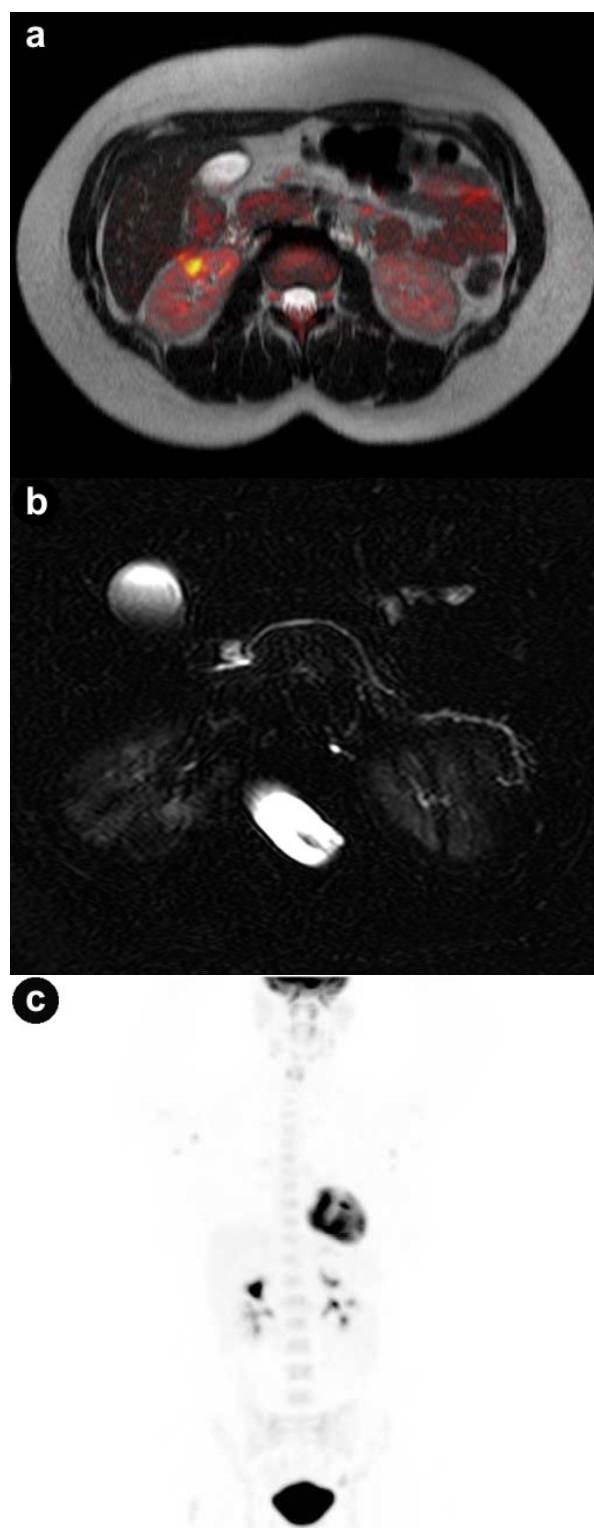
Image following highly active antiretroviral therapy. a. Fusion of axial MRI T2-weighted spin-echo and diffusion-weighted images showing complete resolution of the pancreatic lesions and dramatic regression of the right kidney lesion. b. Axial MRCP showing improvement of the main pancreatic duct abnormalities. c. FDG-PET/CT revealing slight residual radiotracer uptake in the axillary lymph nodes.
